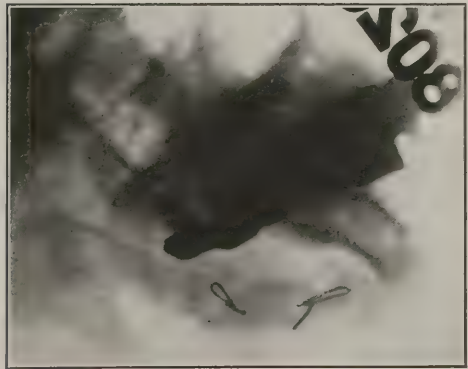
Case 7: Radiograph showing tibial graft in place.
